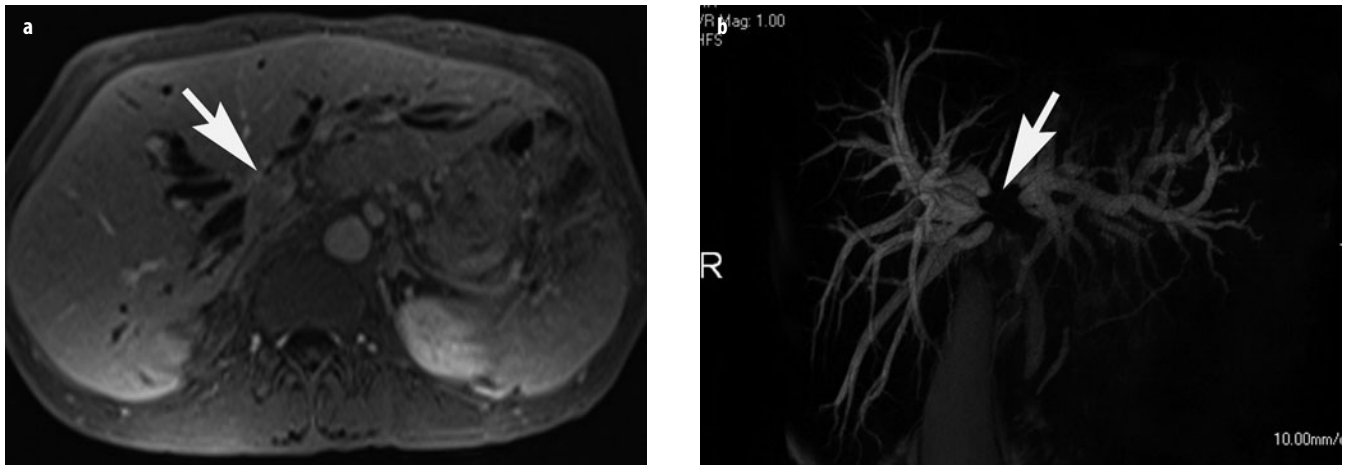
a, b. Hilar cholangiocarcinoma. a Gadolinium-enhanced T1-weighted magnetic resonance image (MRI) (gadolinium administered intravenously) shows dilatation of right and left intrahepatic ducts. The ducts do not converge (*arrow*) to form the common hepatic duct. At this location there is a subtle mass. b Thick-slab magnetic resonance cholangiopancreatography (MRCP) shows a stricture/defect at the confluence of the intrahepatic bile ducts (*arrow*), consistent with a hilar tumor
